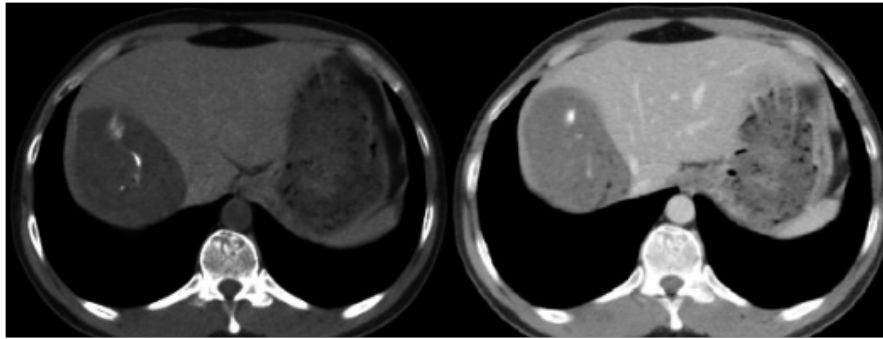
Axial CT images without contrast (a) and with contrast agent (b).
